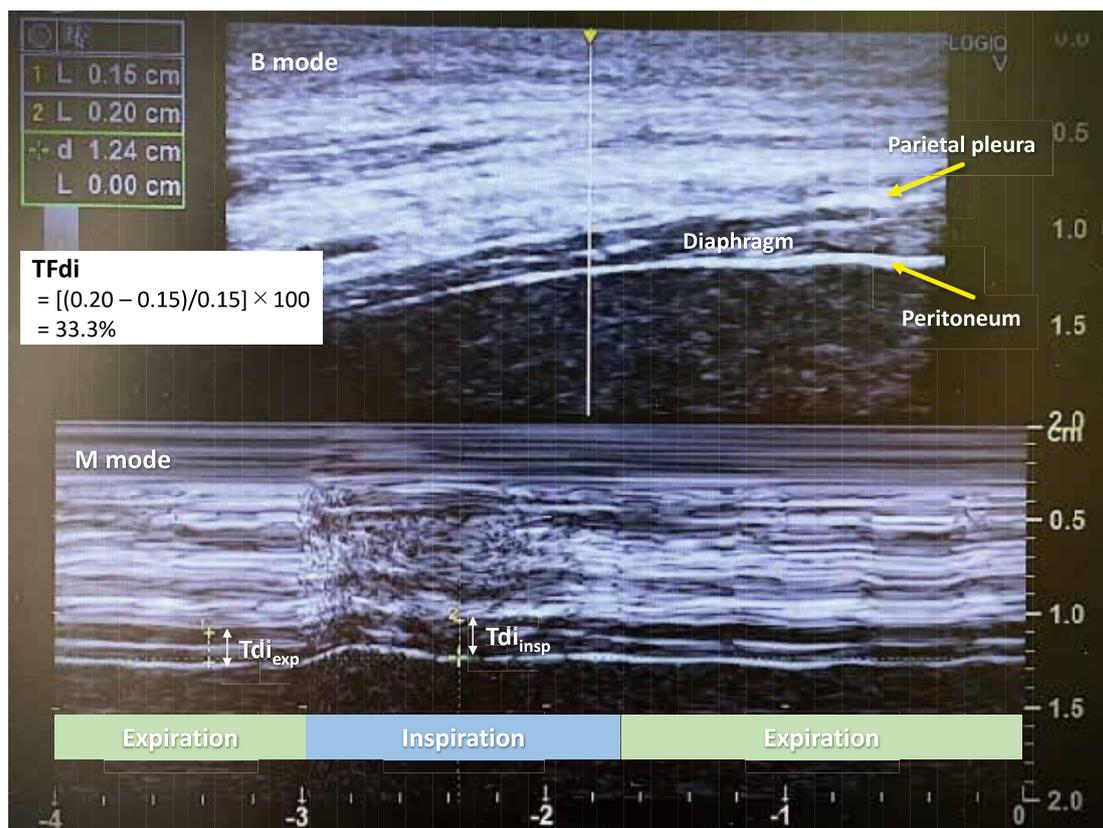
Ultrasonographic assessment of the diaphragm. The diaphragm is a low-echoic layer sandwiched between parietal pleura and peritoneum with a high-echoic centerline. TFdi, thickening fraction of the diaphragm; Tdi_{exp} , thickness of the diaphragm at end-expiration; Tdi_{insp} , thickness of the diaphragm at end-inspiration.
